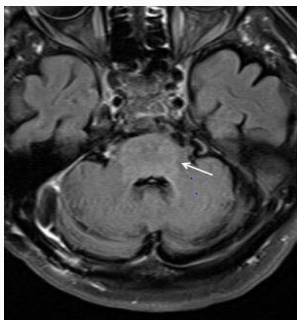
Hyper intense diffuse tumor in the pons in FLAIR images (white arrow) without evidence of contrast enhancement.
